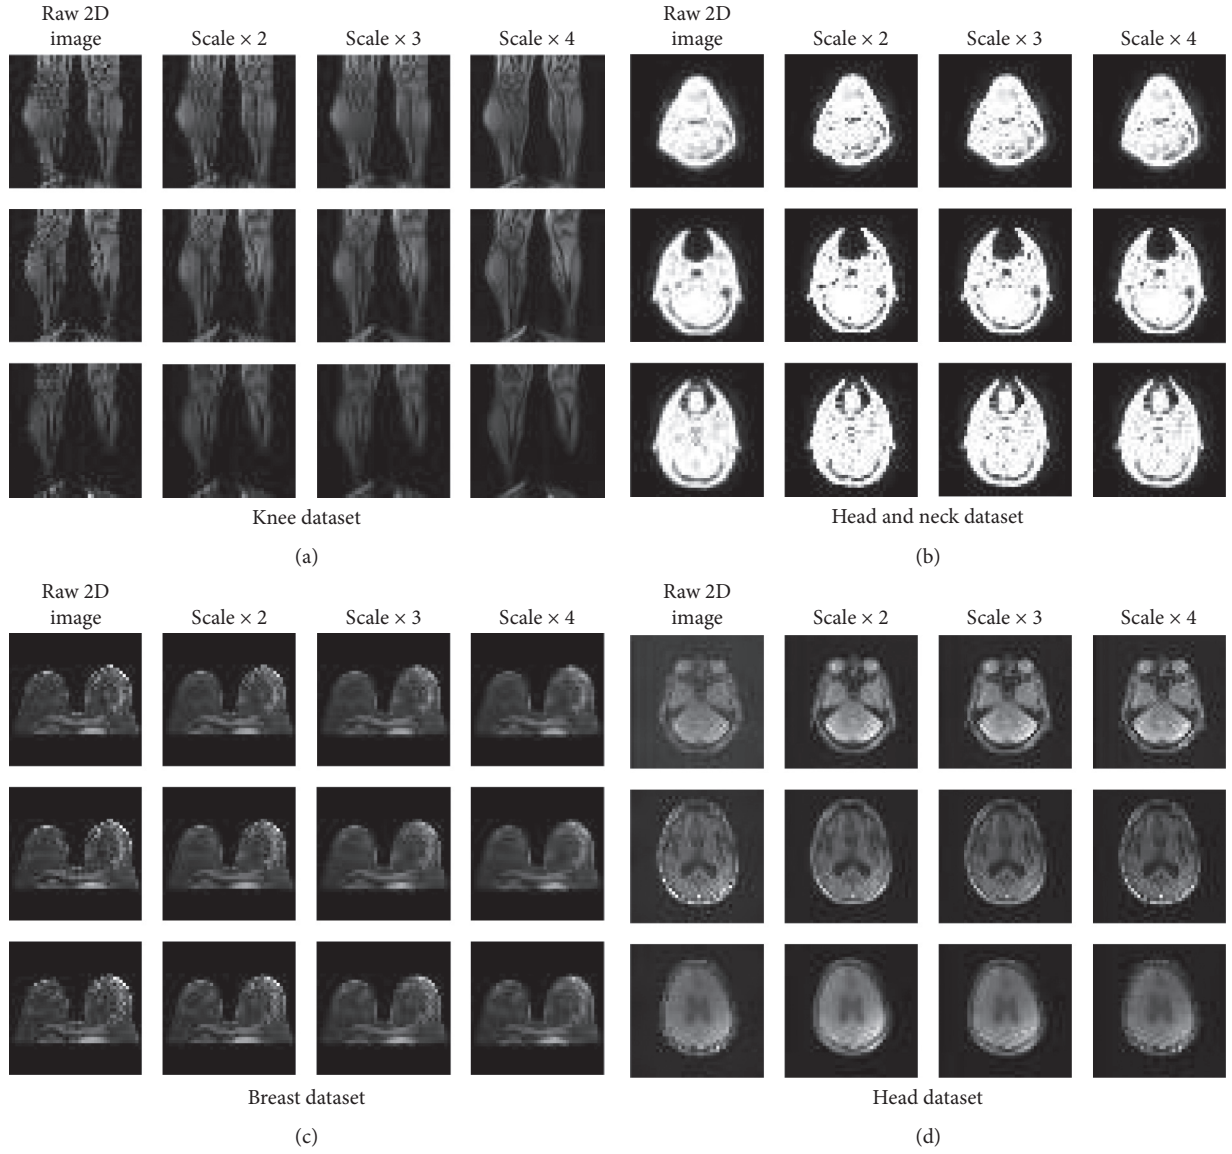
MR image super-resolution pairs, including three different high-low resolution pairs of MR images.
